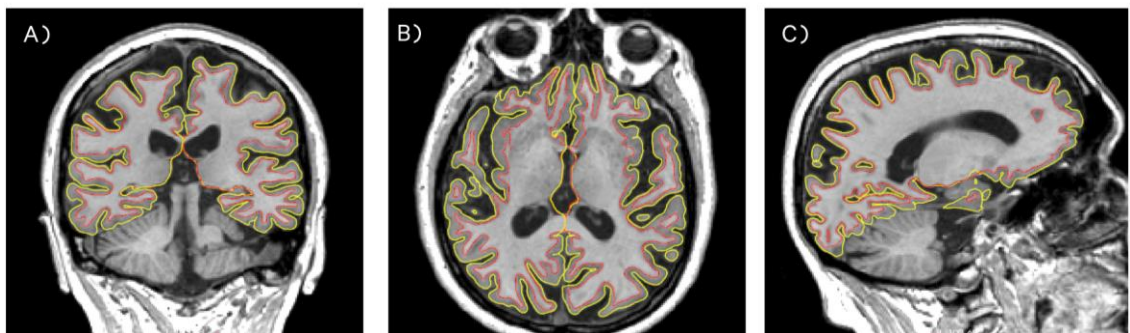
An example of a FreeSurfer CT segmentation for a participant showing disease related atrophy shown in A) coronal, (B) axial and (C) sagittal views. Underestimation of the GM is particularly pronounced in the coronal and sagittal views.
